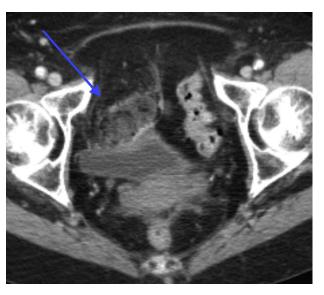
Evolution of fat necrosis anterior the bladder (blue arrow) approximately 6 weeks later (CT scan 10/9/2013).
